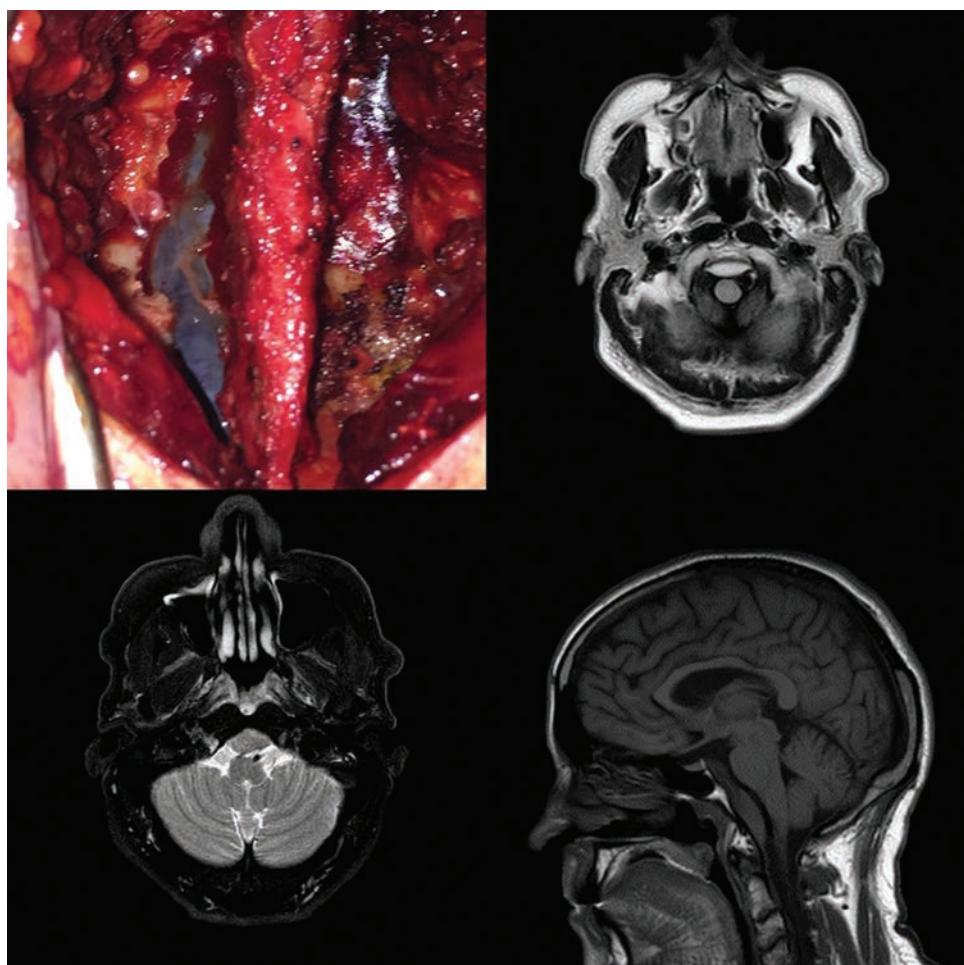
(A) Intraoperative image of hematoma drainage. (B, C, and D) Axial FLAIR sequence, T1-weighted and sagittal T2-weighted magnetic resonance images of a retroclival subdural hematoma. Abbreviations: FLAIR, fluid attenuation inversion recovery.
